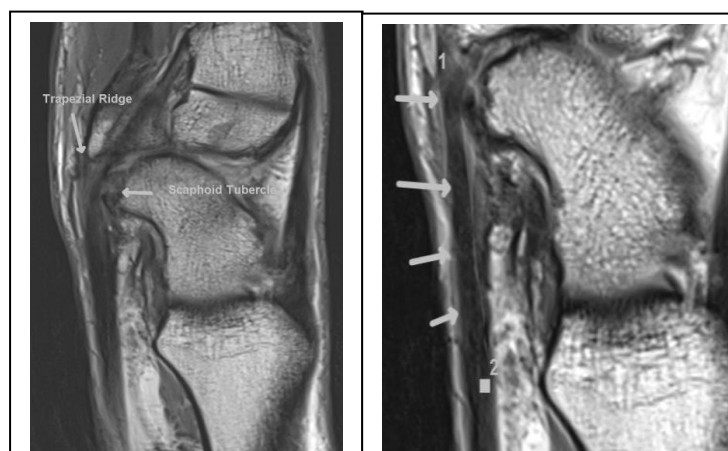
MRI Sagittal Proton Dense showing large scaphoid tubercle, (spur-like) with compression of FCR (arrowed) as it dives under the thickened trapezoidal ridge.
